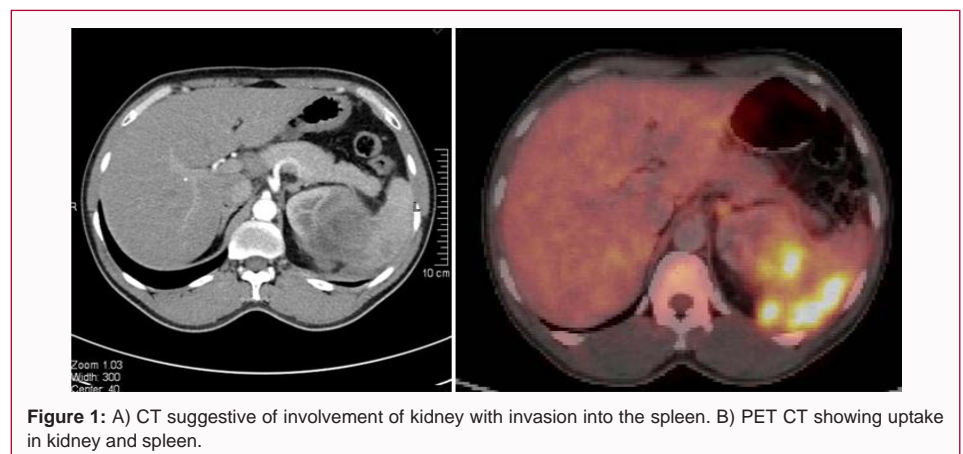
A) CT suggestive of involvement of kidney with invasion into the spleen. B) PET CT showing uptake in kidney and spleen.
